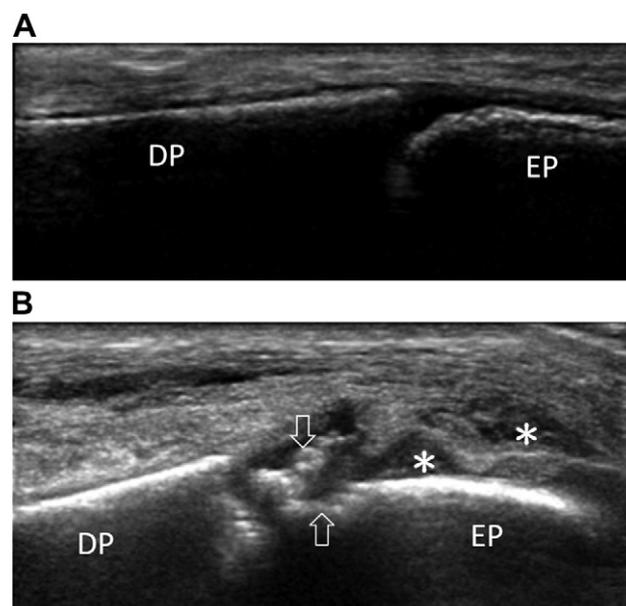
Sonography of a 12-year-old skier on Day 4 after a sprain to his right lateral ankle. The X-ray picture did not reveal any bony fracture at his right ankle. (A) Ultrasound image of his asymptomatic left ankle shows smooth bony cortex at diaphysis (DP) and epiphysis (EP). (B) Fracture of the proximal end of the epiphysis (open arrows) with subperiosteal hematoma (*) and marked soft tissue swelling are noted at his right ankle.
